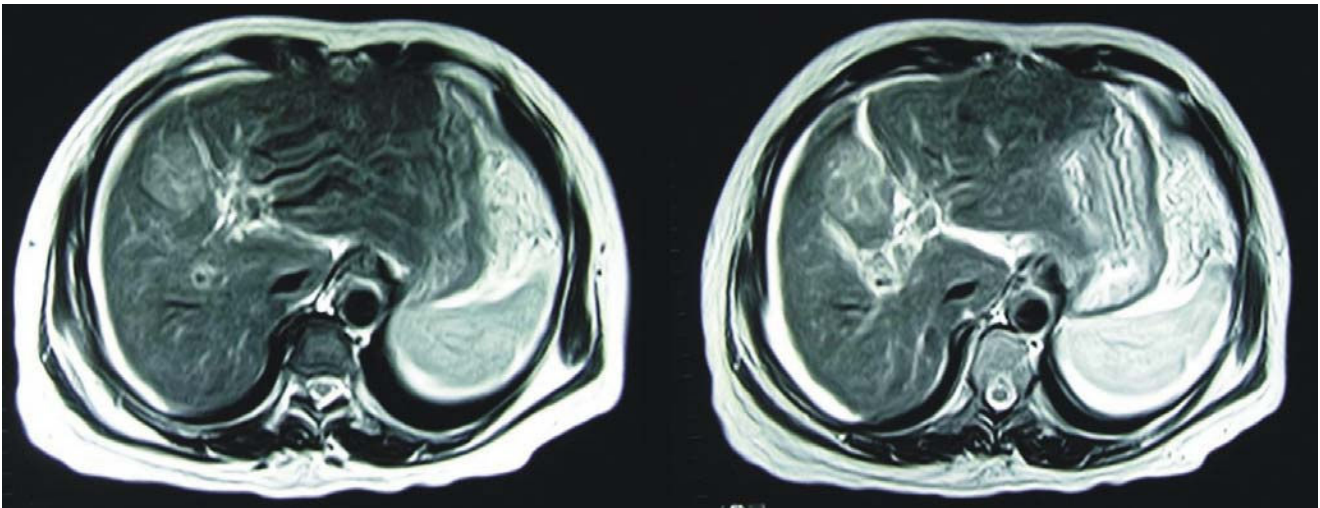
Magnetic Resonance Imaging showed a hypointense lesion in T1 sequences that enhances in T2 sequences as a hepatocellular carcinoma of 6 vs 5 cm. S
